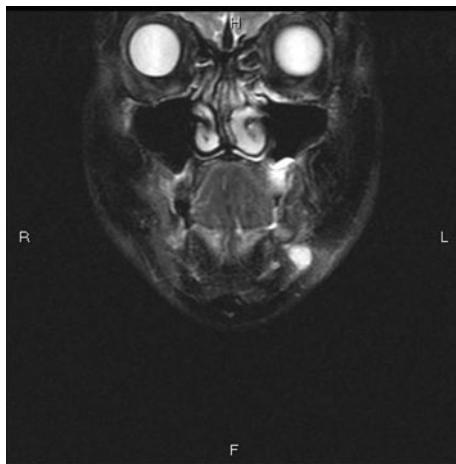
Coronal section of MRI (not enhanced). A 1 cm tumor is seen in the *left* mandibular oral area
